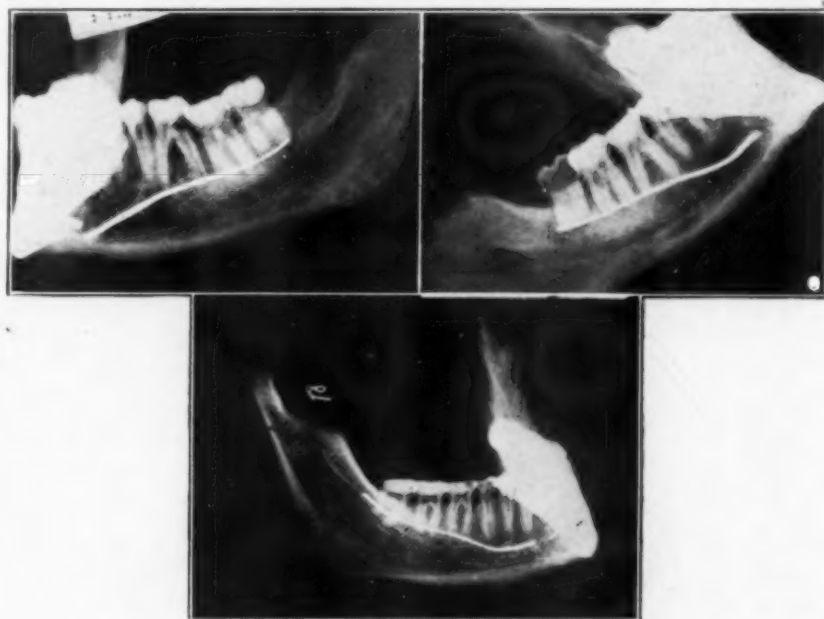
Roentgenograms showing the relation of the tips of the roots to the mylohyoid ridge.
